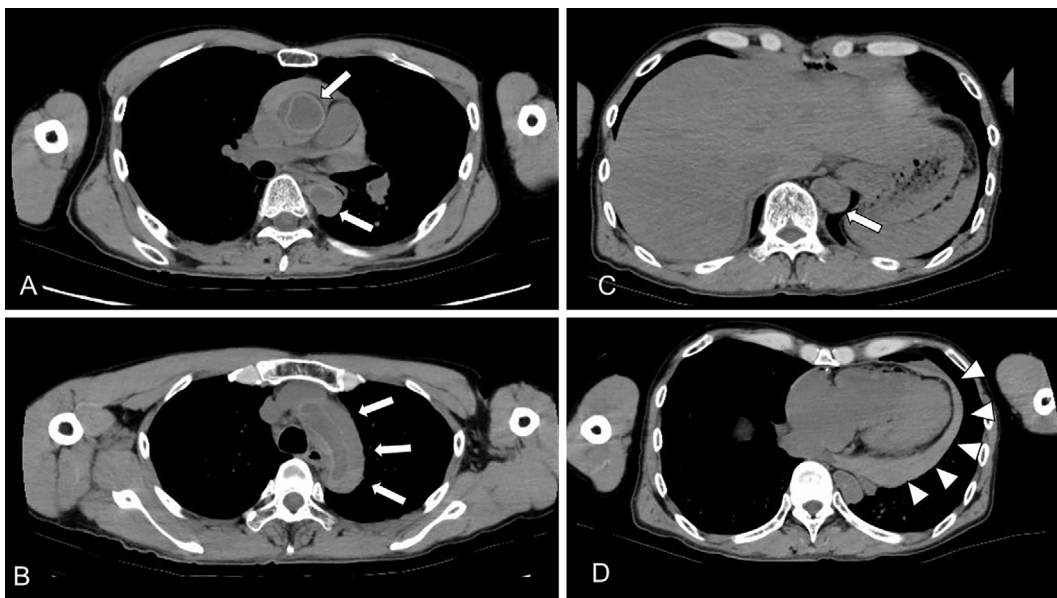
Whole-body CT after death. A-D) Consecutive axial non-contrast CT whole-body images showing extended arterial dissection not only at the brachiocephalic artery but also from the ascending aorta to the descending aorta just before the celiac artery (arrows). Massive pericardial effusion is also visible (arrowheads). CT: computed tomography
